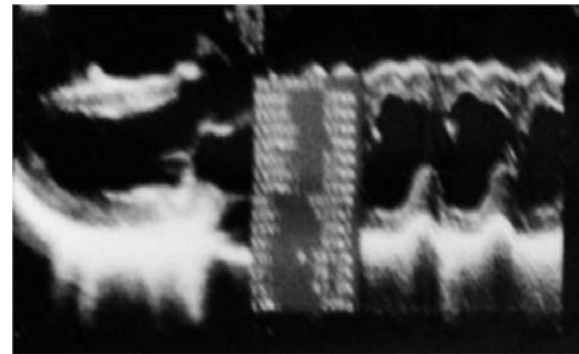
Echocardiography found vegetation in tricuspidal valve
